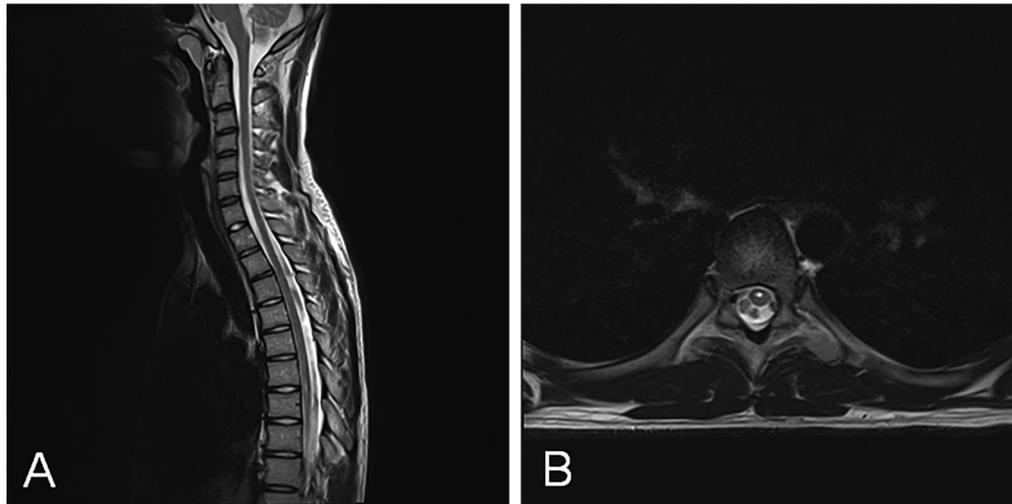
Spine MRI taken a year before admission due to abnormal sensations. Sagittal (A) and axial (B) T2-weighted images revealed syrinx at the T6-7 level with subtle T2 hyperintensity at the T5-T9 level.
